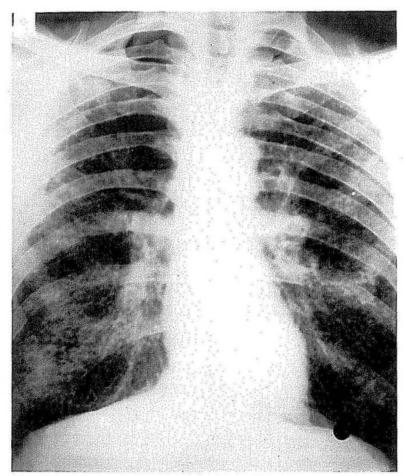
Chest radiograph of Welsh lead miner with heavy exposure to silica dust. Radiograph taken in 1952, showing category 3/3 simple silicosis. At this stage the man left the industry.
